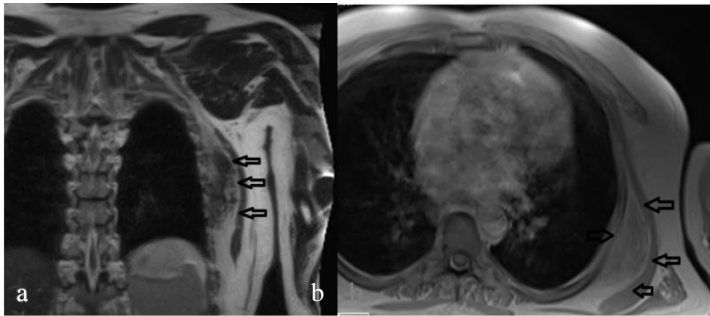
In the chest magnetic resonance imaging, there is a heterogeneous mass lesion which was located longitudinally between the ribs and serratus anterior muscle at the left side and isointense with muscles. a: Coronal plain, b: Axial plain
